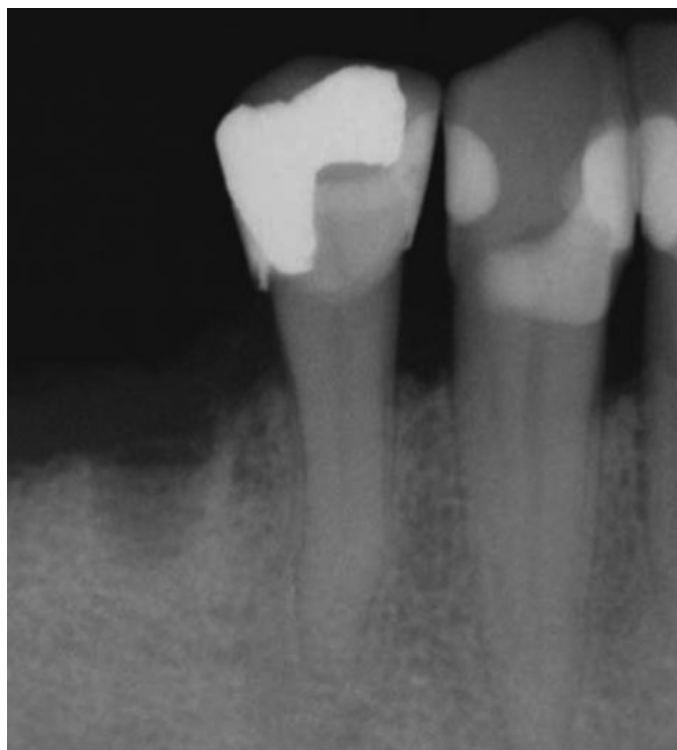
(A) Pretreatment radiograph of a mandibular premolar shows one canal.
